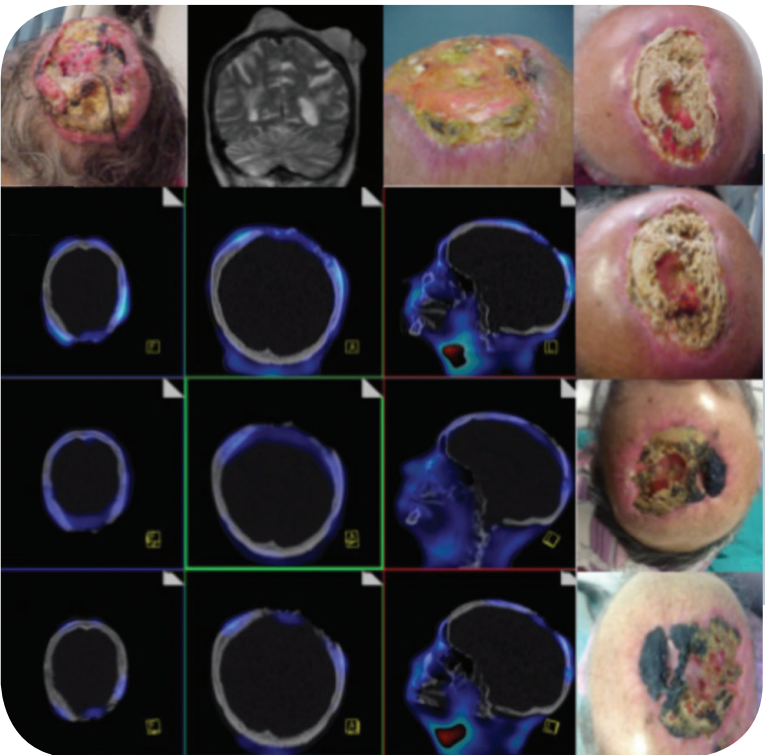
(A) 82 years old female, diagnosed with squamous cell cancer of the scalp. In MR imaging, there is no evidence of intracranial or meningeal involvement. She was treated with radiation therapy. However, the patient developed grade IV radiation necrosis with bacterial superinfection. Treatment was initiated with amoxicillin-clavulanate. Monitoring of the response was carried out with 99mTc-UBI [29-41] SPECT / CT, with initial image that shows focal uptake in the primary lesion (B) with diminished uptake in subsequent studies every 2 months (C and D) that correlates with the clinical improvement (last row). (INCan, 2013-2014).
